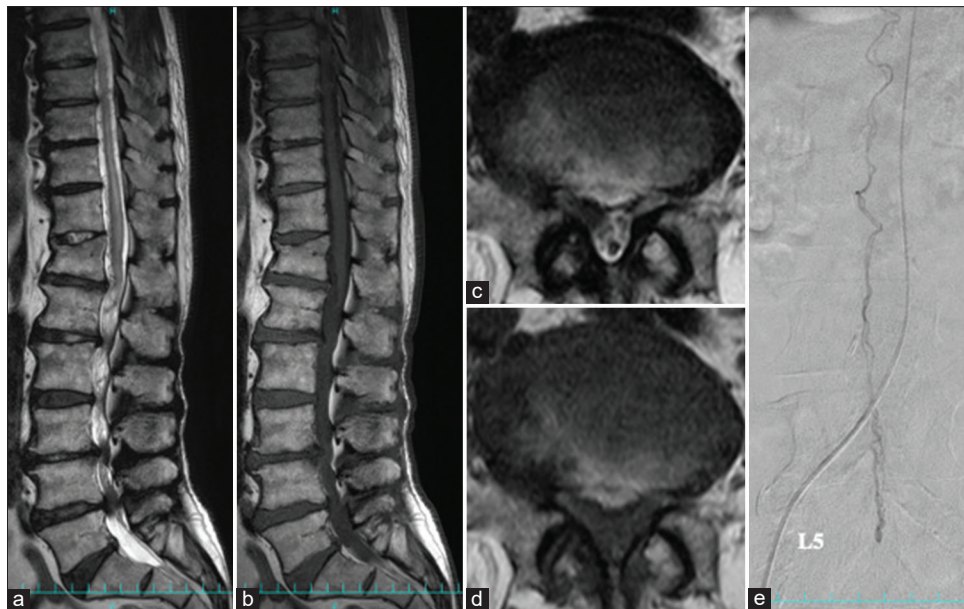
Filum terminale arteriovenous fistula at L5 (Case 1). (a) Sagittal T2-weighted magnetic resonance image (MRI) shows the swollen spinal cord surrounded by flow voids. It also shows redundant cauda equina and spinal canal stenosis from L3 to L5. (b) Sagittal T1-weighted MRI does not show high signal intensity in the filum terminale. (c and d) Axial T1- and T2-weighted MRIs at L5 indicate thickened filum terminale due to edema, although the fatty component is not evident. (e) Selective catheter angiography from left T10 intercostal artery shows an arteriovenous fistula located at L5 that is fed by a caudally running artery in the filum terminale. The drainer is a vein in the filum terminale with an ascending flow.
